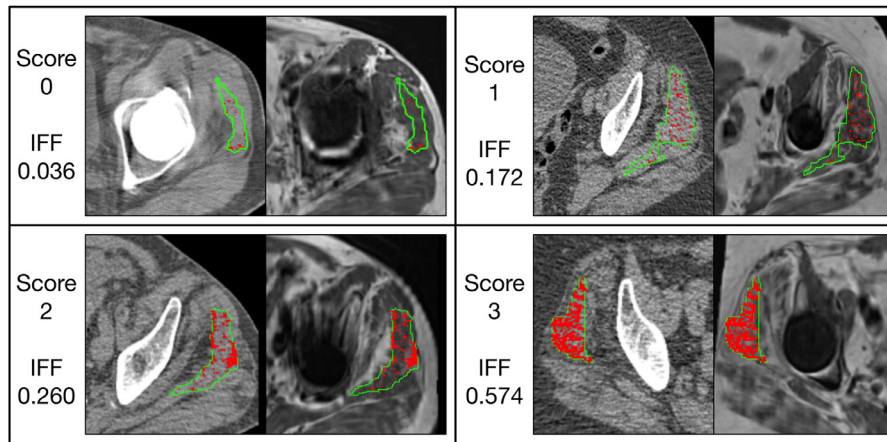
Examples of registered CT and MRI for each radiological score, and the automated fat segmentation from the proposed method. The eroded gross muscle boundary is reported in green, while in red is the fat segmentation. The derived IFF is also reported, showing an increase of fat infiltration in agreement with the radiological score.
